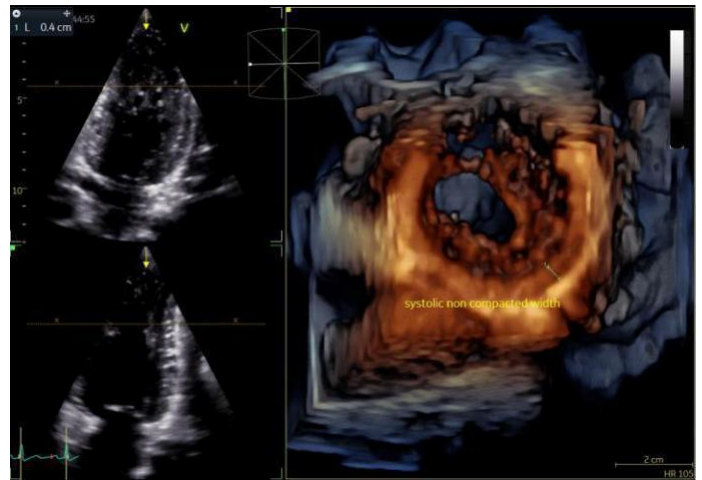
2D and 3D echocardiography with measurement on the systolic non-compacted width
